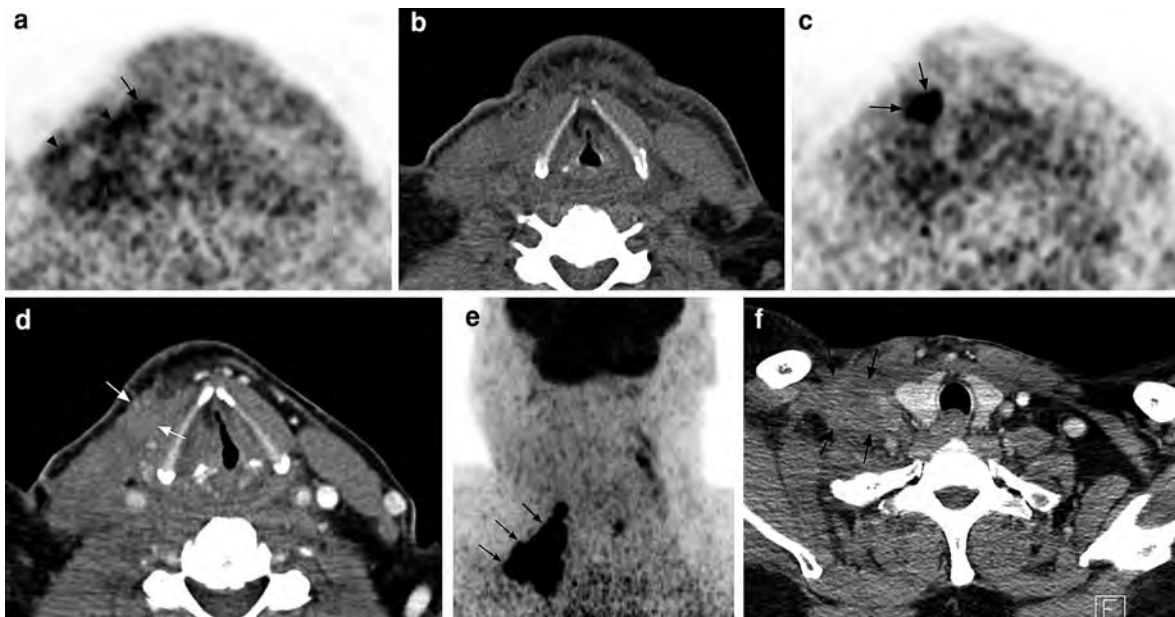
Axial PET image (a) performed 4 weeks after lymph node dissection shows patchy areas of marked FDG uptake (arrow and arrowheads in a) within the right lateral neck compartment without evidence of focal lesions on the non-enhanced CT image (b) at the same level. Such FDG uptake could be related to post-surgical inflammation/granulation tissue or persistent tumor. The PET examination was repeated 3 months later (c) revealing a discrete area of intense FDG uptake (arrows in c) within the region of the more anterior FDG uptake on the prior study (arrows in a) while the more posterior
